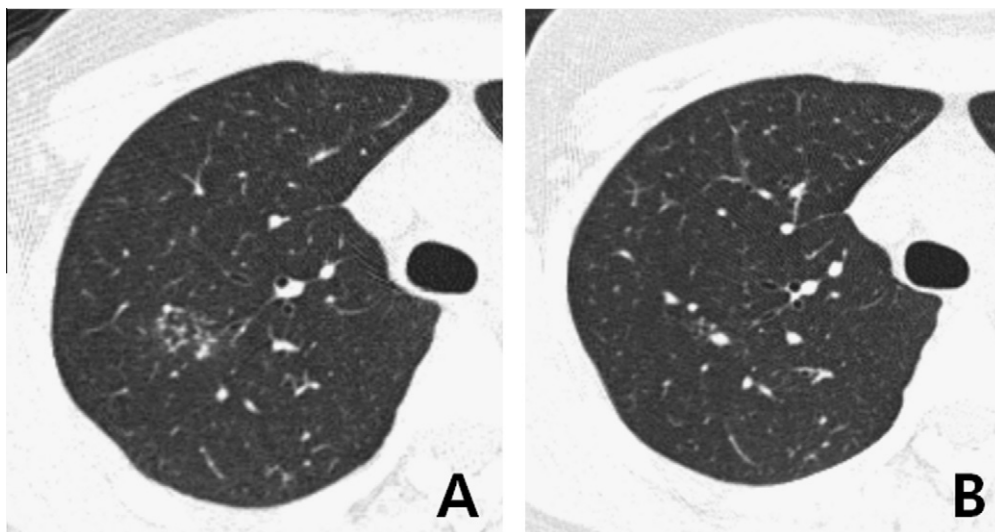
HRCT at presentation (A) and thereafter in 6 months (B). Although invisible in the simple chest radiography, subtle infiltration in the right upper lobe suggesting active pulmonary tuberculosis was seen in HRCT at presentation, which was cleared up in 6 months of anti-tuberculosis therapy.
